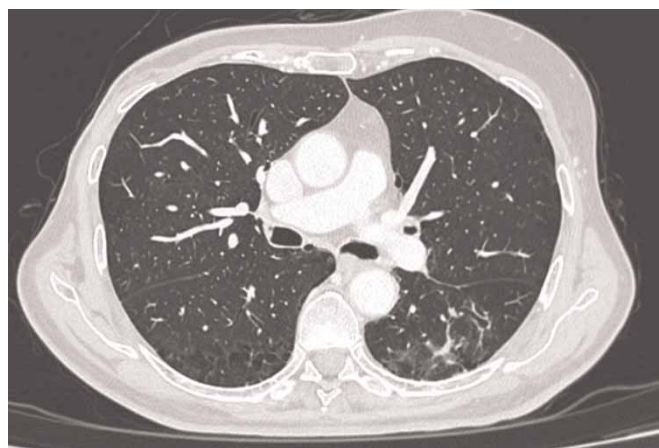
Follow-up chest computed tomography obtained after corticosteroid therapy and ribociclib discontinuation, showing near-complete resolution of the previously described lesion with minimal residual fibro-atelectatic changes.
